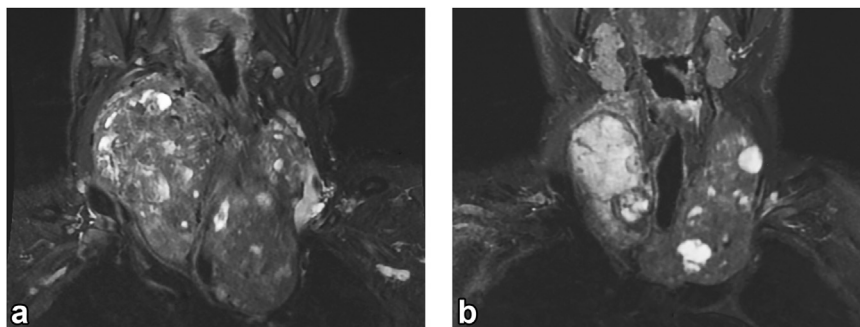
In a 55-year-old man with a large retrosternal goiter and hyperthyroidism (thyroid-stimulating hormone [TSH], 0.008 mIU/L), the T2-weighted coronal magnetic resonance image (a) shows the retrosternal goiter (right lobe = $15.5 \times 9.1 \times 6.8$ cm [volume, 479 mL]; left lobe = $12.4 \times 6.3 \times 4.0$ cm [volume, 156 mL]). The patient underwent embolization of the right superior and bilateral inferior thyroid arteries. He developed temporary hyperthyroidism for several weeks, but at 3 months, his TSH levels became normal (1.7 mIU/L). At 6 months, the coronal T2-weighted image (b) demonstrated a marked shrinkage of the goiter mass (right lobe = $9.24 \times 3.9 \times 4.7$ cm [volume, 84 mL]; left lobe = $9.8 \times 3.0 \times 4.7$ cm [volume, 69 mL]). The volume reduction was 82.5% in the right lobe and 56% in the left lobe. The intrathoracic extension was also reduced from 8 cm to 5 cm (37.5% reduction). After the embolization, the patient became asymptomatic and remained euthyroid throughout the follow-up.
